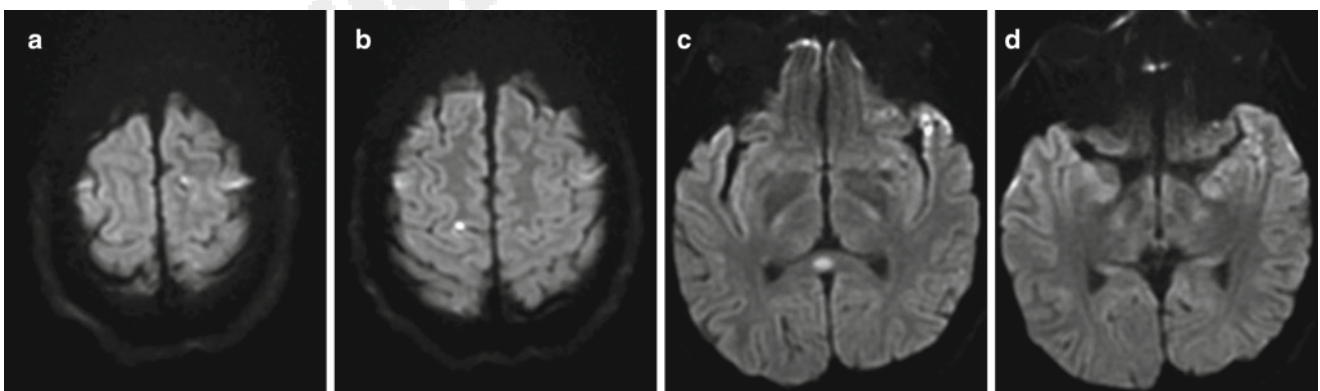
Traumatic brain/shear injury. (a–d) Axial DWI images demonstrate punctate DWI hyperintense foci at frontal gray white matter junctions bilaterally as well as a lesion in the splenium of corpus callosum in this patient who was evaluated following a closed head injury
